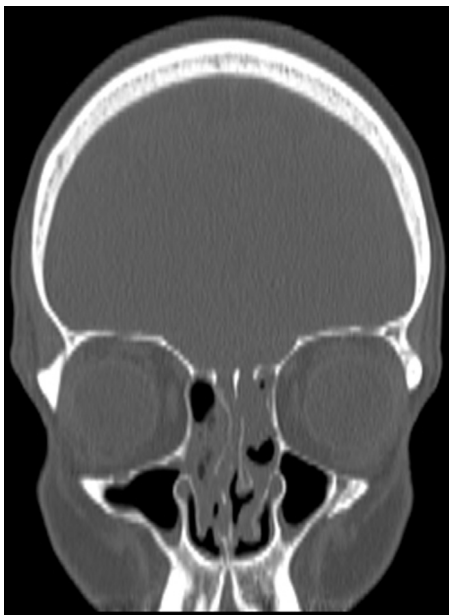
CT scan of an iatrogenic leak in the lateral lamella on the patient's left side.
